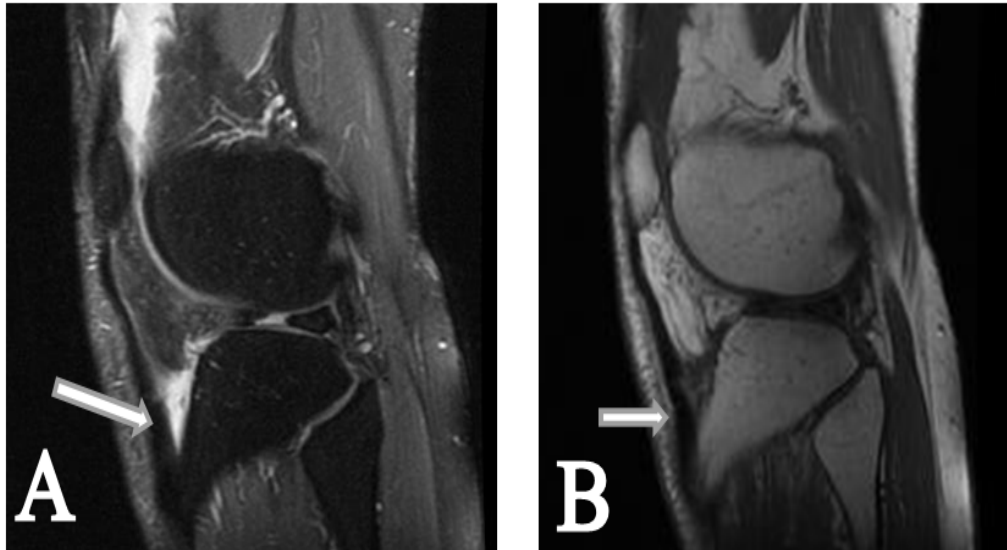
A. sagittal PD weighted image, B. sagittal T1-weighted image showing well defined hyperintense cystic lesion (arrow) in infra-patellar region with its apex between the inferior patellar tendon and anterior tibial margin with associated knee effusion
